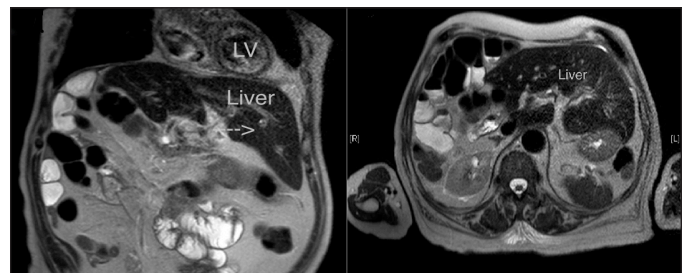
Longitudinal and cross-sectional MRI showing the liver and gallbladder on the left side, with pancreas, duodenum, and spleen in a normal anatomical position.
